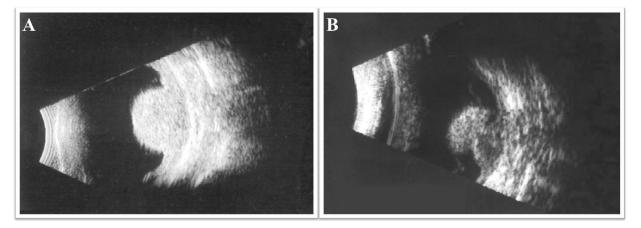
B-scan Ultrasound Images of Choroidal Melanoma. A) The choroidal melanoma demonstrates a mushroom-shaped growth. B) The tumor shows an excavation sign.
